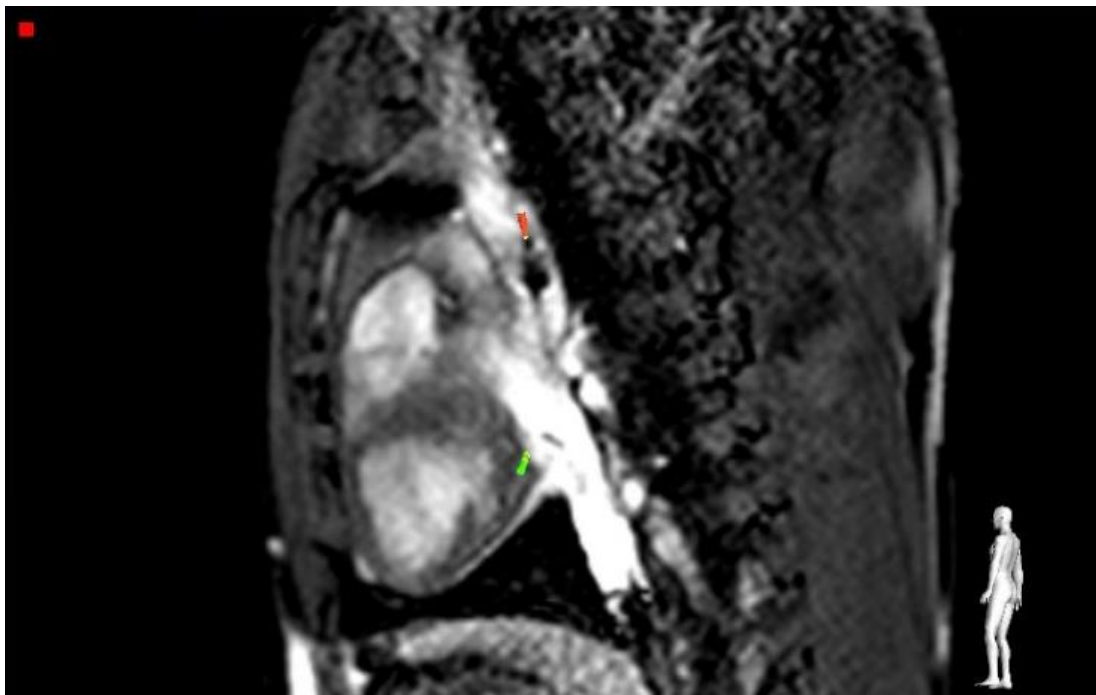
Real-time sagittal MR image confirming the red tracked catheter tip position as a signal void.
